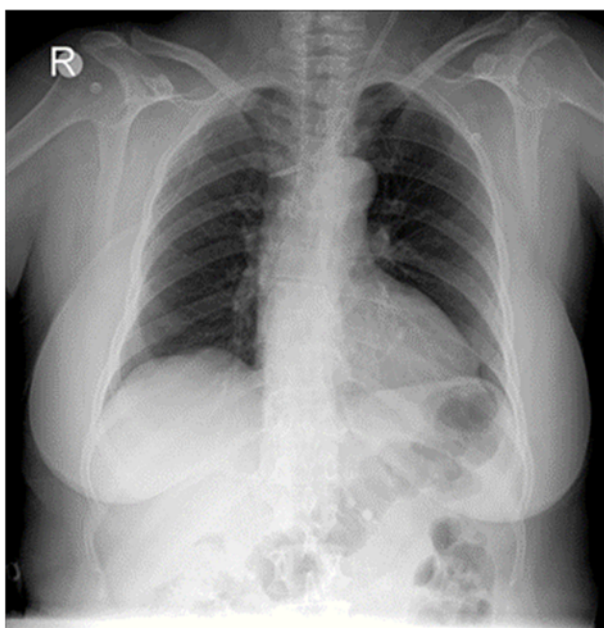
PA-Chest X-ray after catheter tip removal
